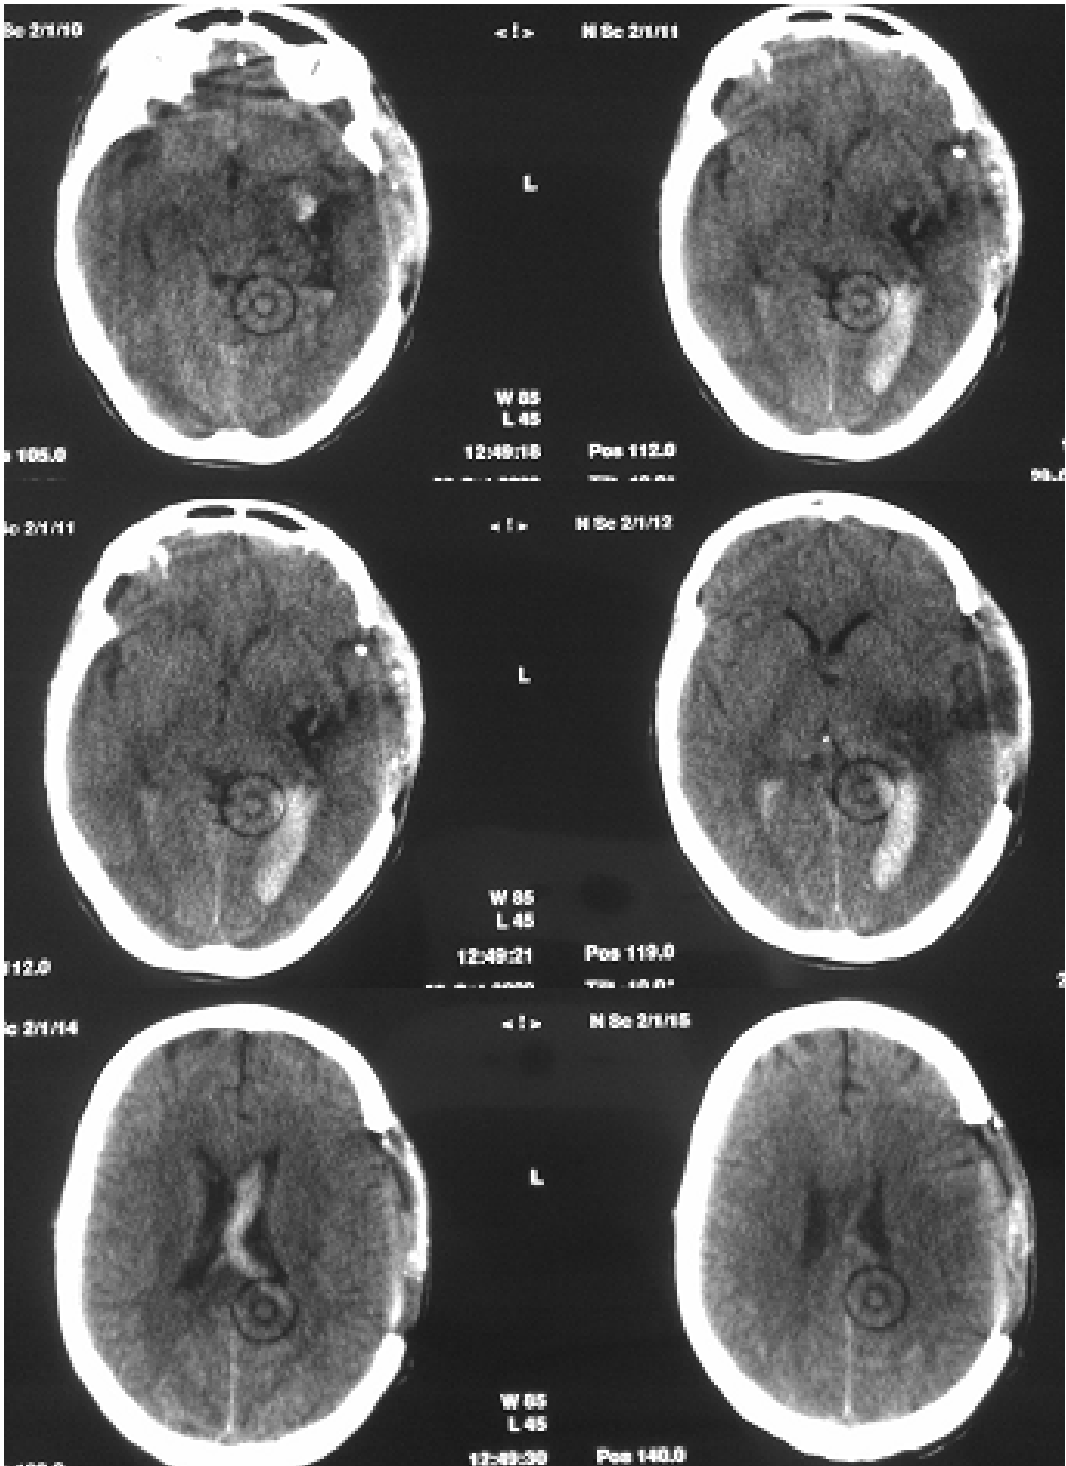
Cerebral CT scan, left temporal hipodensity, intraventricular hemorrhage, decompressive craniectomy
